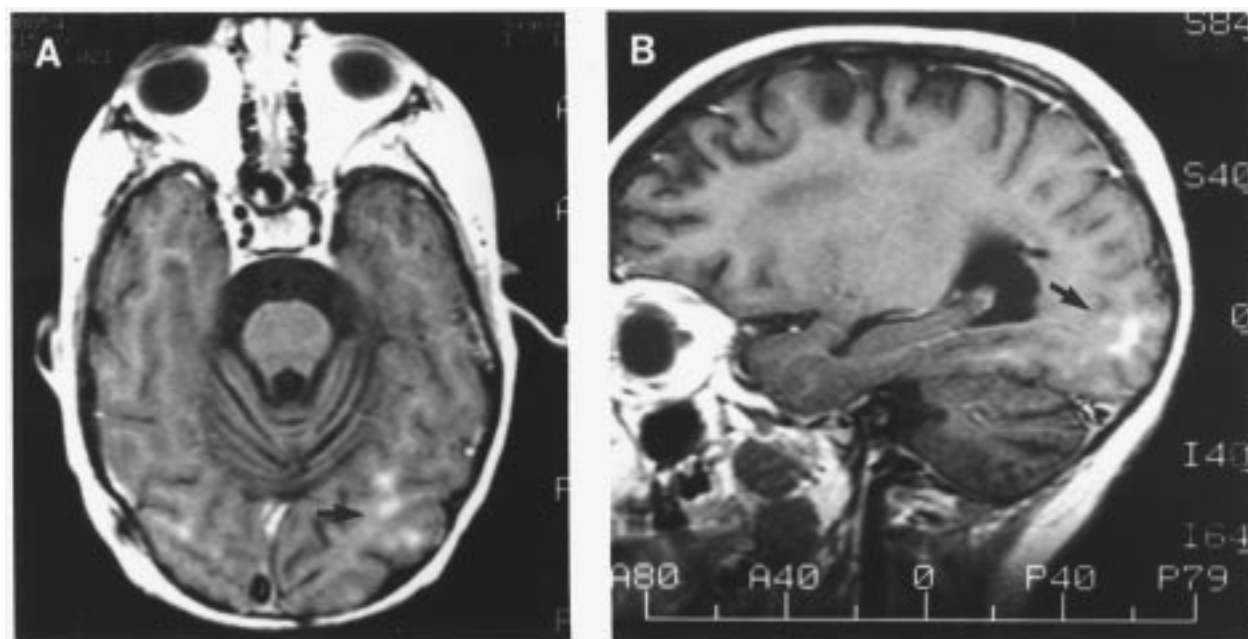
A: T1-weighted axial postcontrast MR image shows abnormal punctate enhancement involving the occipital lobes bilaterally. B: T1-weighted sagittal postcontrast MR image shows similar finding in the right occipital lobe. Findings are suspicious for leptomeningeal dissemination of tumor.
